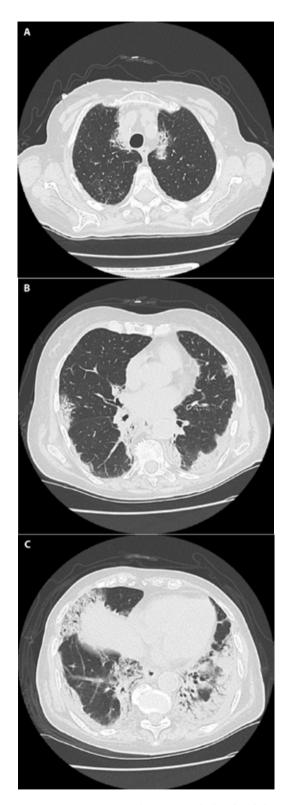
CT scan on admission with details of the apical (A), middle (B) and basal (C) regions and evidence of pulmonary involvement with increasing cranio-caudal gradient.
